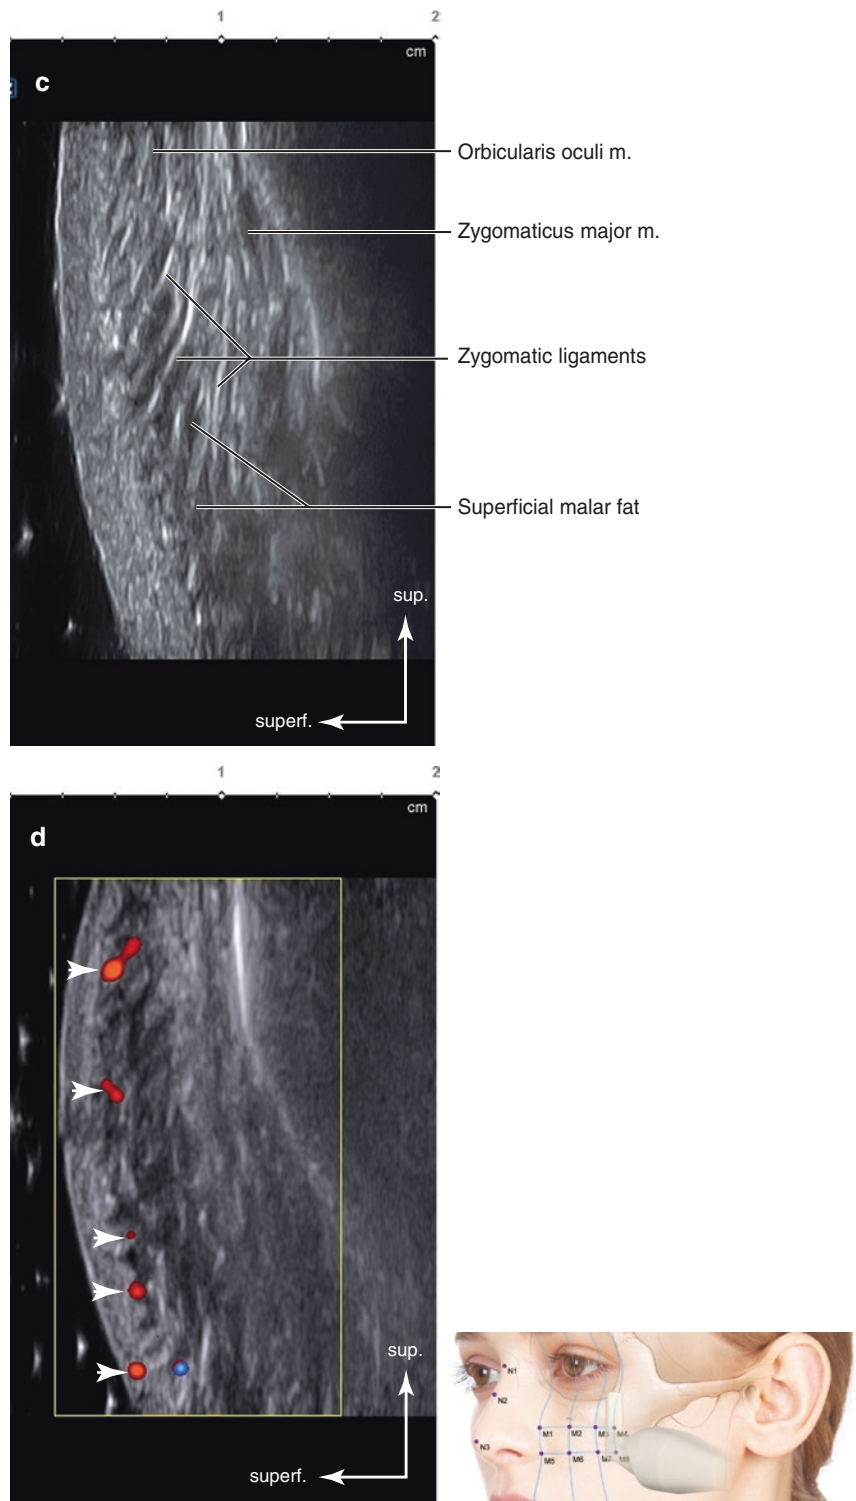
Ultrasonography on the intersection point of TL4 and PL4 (M4). (a) B mode (transverse view, 15 MHz by linear transducer), (b) Doppler mode (transverse view, 15 MHz by linear transducer), (c) B mode (sagittal view, 15 MHz by linear transducer), and (d) Doppler mode (sagittal view, 15 MHz by linear transducer) (arrowheads: perforators). (Published with kind permission of © Hee-Jin Kim 2020. All Rights Reserved)
